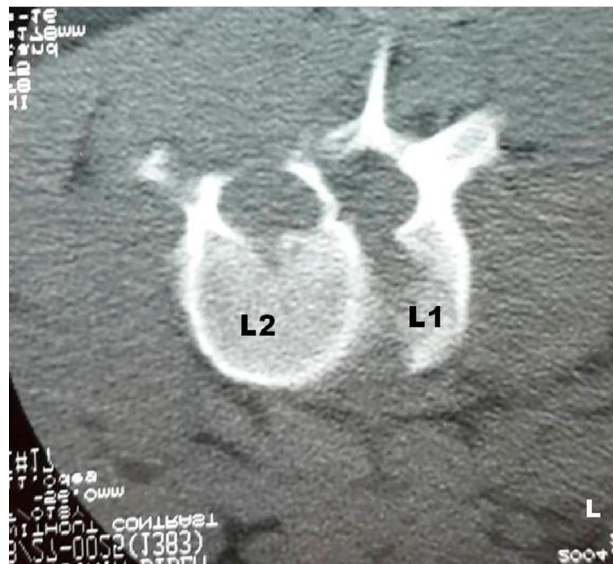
Coronal MR image demonstrating complete fracture dislocation at thoracolumbar region (upper). Sagittal MR image showing marked rotation at thoracolumbar region (lower left), axial MRI showing double body appearance (lower right), note that despite marked dislocation of the bodies, the neural arches are minimally displaced.
